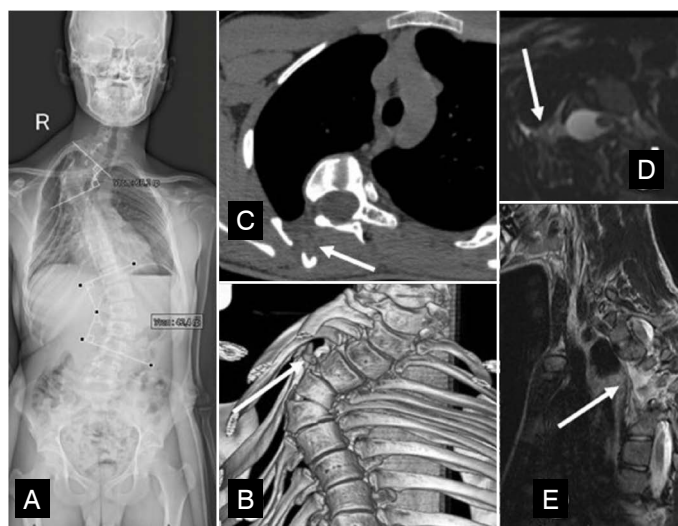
Preoperative Imaging: Case 1. (A) X-ray of the spine revealing scoliosis; (B) 3D CT reconstruction of the upper thoracic spine depicting features of dystrophic scoliosis; (C) CT slice through the apex of the deformity, displaying dystrophic bone changes and intrathoracic pathological tissue (indicated by the white arrow); (D) Axial MRI slice through the apex of the deformity highlighting dural ectasia and pathological intrathoracic tissue in the apex of the right lung (indicated by the white arrow); (E) Sagittal MRI slice at the level of the spinal deformity unveiling pathological intrathoracic tissue in the posterior apex of the right lung (indicated by the white arrow).
